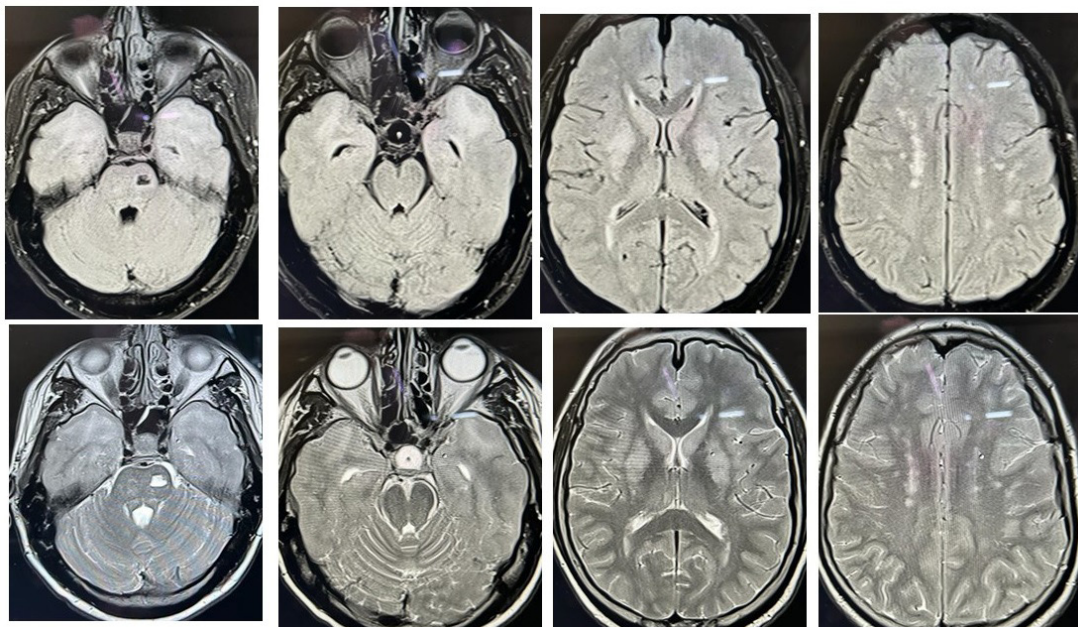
MRI: T2 & FLAIR images show multiple foci of hypointensity in the white matter of bilateral frontal and parietal lobes. Characteristic anterior temporal white matter hyperintensity is also noted. Nearly symmetrical hyperintensity in bilateral basal ganglia is seen. Chronic lacunar infarct and poorly defined foci of hyperintensities are seen in the pons.
